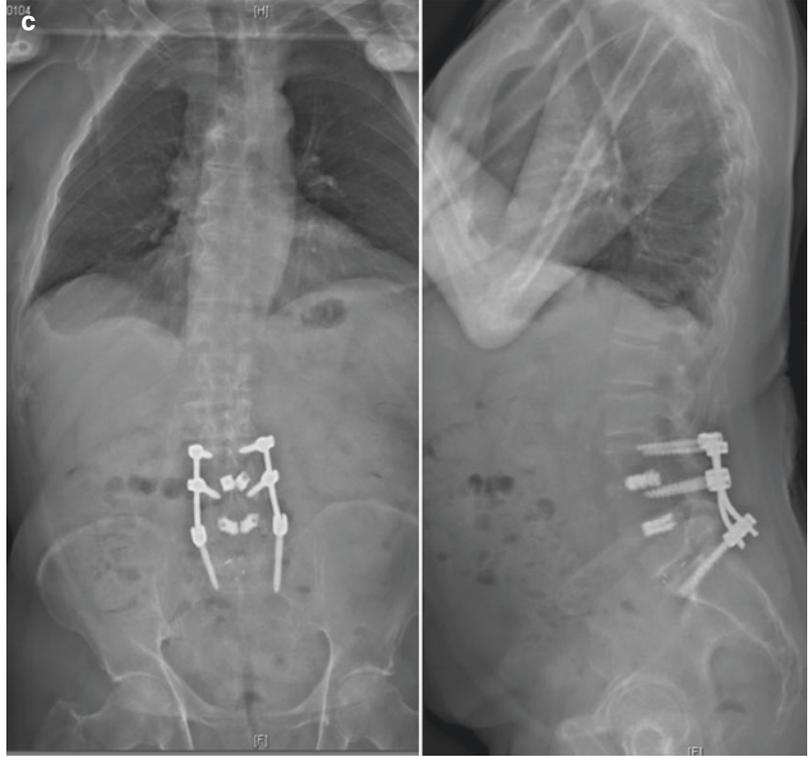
Upright standing lateral total spine X-ray in (a) 2016 and (b) at 6 months follow-up after conservative treatment of a sacral fracture
